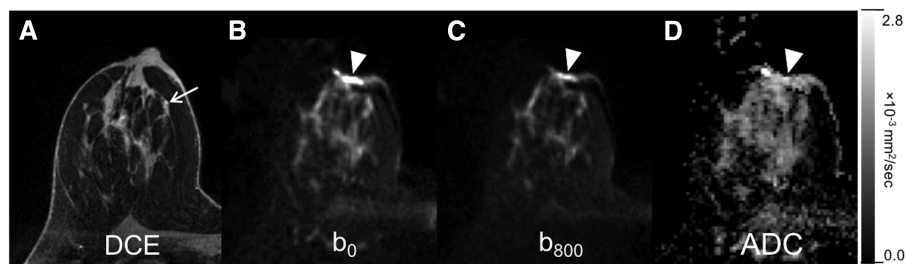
Example of diffusion-weighted imaging (DWI) data with aliasing, which can be identified by repeating parenchyma in the image along the phase encoding direction. Dynamic contrast-enhanced (DCE) MRI (A) in a 65-year-old woman undergoing 3T MRI for short-interval follow-up for bilateral BI-RADS category 3 enhancing foci, such as the one shown in the left breast (arrow). On DWI (B and C) and the apparent diffusion coefficient (ADC) map (D), repeated signal from the breast fibroglandular tissue is observed in the phase-encode (antero-posterior) direction, particularly across the right breast (B and C, arrowheads).
